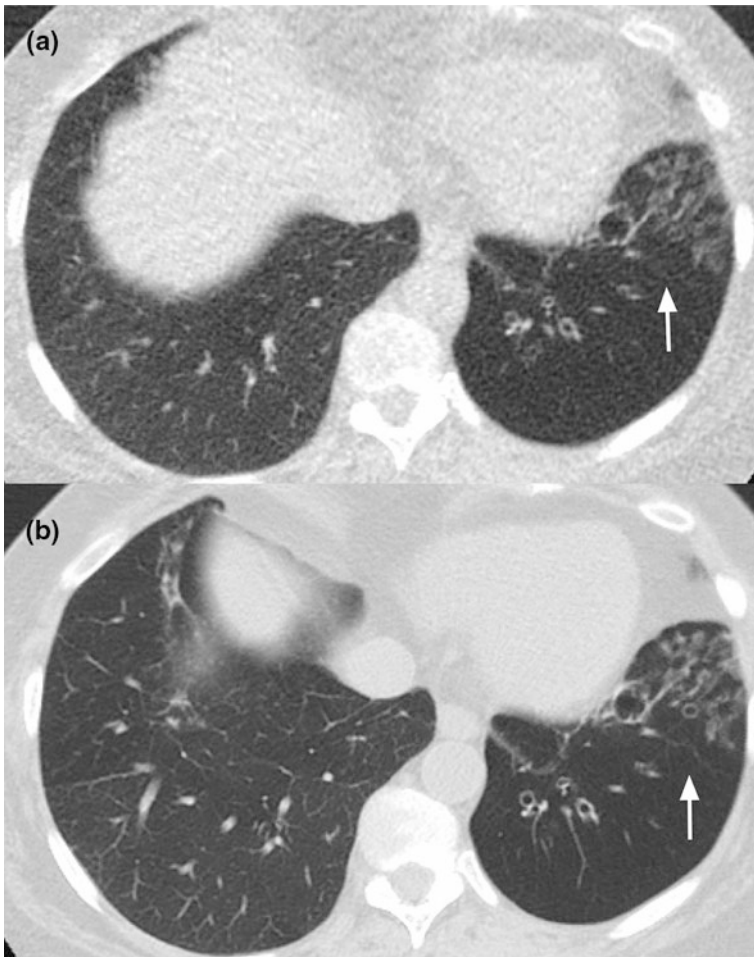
a Ultra-low dose chest CT showing bronchiectasis in the left lower lobe (white arrow) at a dose of 0.2 mSv. b Previous study on an older CT scanner shows the same bronchiectatic changes (white arrow) at a dose of 2.5 mSv. There is increased image noise in the ultra-low dose scan, but image detail is sufficient for diagnosis
